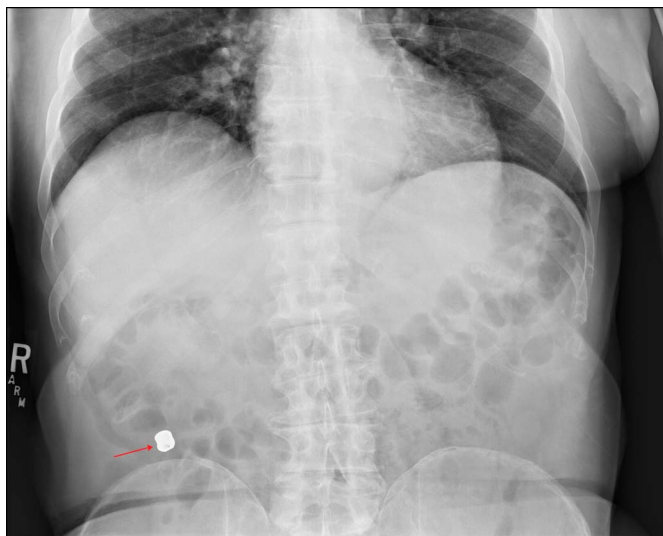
X-ray of the abdomen demonstrating square-shaped lucency in the right lower hemiabdomen representing the metallic tooth crown.
